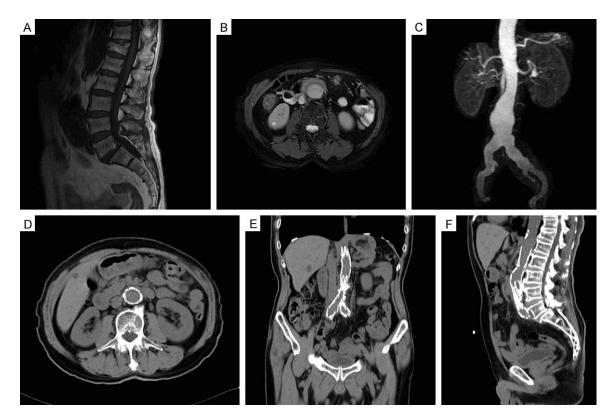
72-year-old male patient diagnosed as AAA. A: The sagittal image of lumbar MRI showed lumbar spondylolisthesis of L5, meanwhile, a dilated abdominal aorta was observed. B, C: An MRA of abdominal aorta confirmed the AAA with thrombus in lumen affecting the cauda equina. D-F: The Abdominal CT showed the AAA was well handled at 12 m-follow-up after EVAR.
